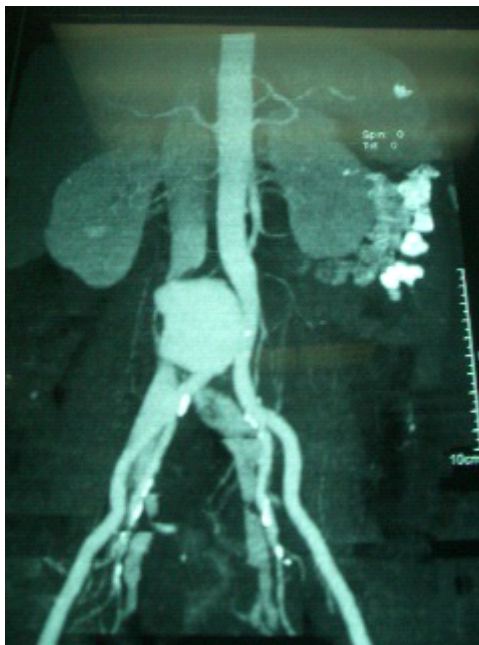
Preoperative abdominal computed tomography angiogram showing large saccular abdominal aortic aneurysm and aortocaval fistula
